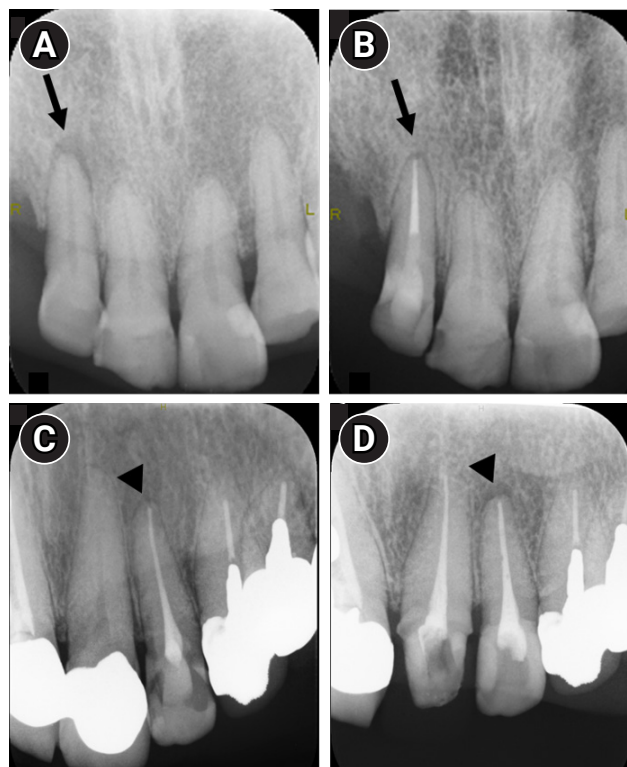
Representative pre- and postoperative dental radiographs showing good and poor outcomes. Preoperative (A) and postoperative (B) radiographs of a maxillary right lateral incisor (arrows). The 1-year and 4-month follow-up radiograph demonstrates a good outcome. Preoperative (C) and postoperative (D) radiographs of a maxillary left lateral incisor (arrowheads). The 7-month follow-up radiograph shows a poor outcome.
